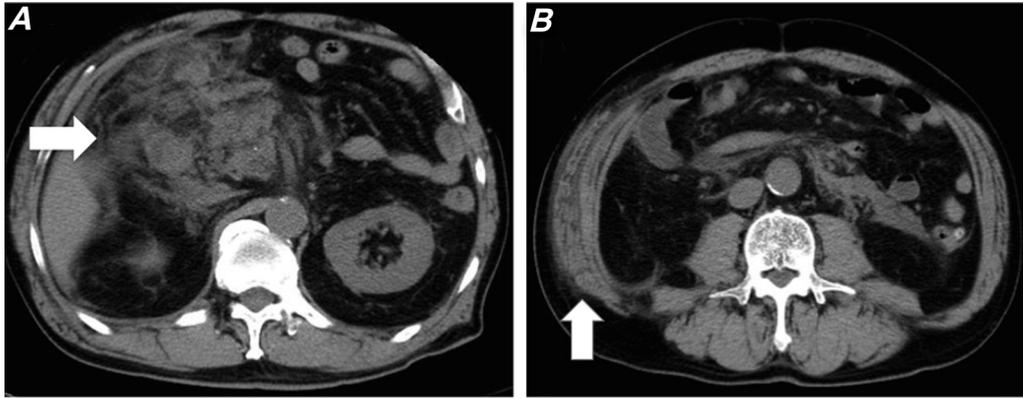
Abdominal noncontrast computed tomography (CT). An abdominal CT revealed an extension of extra pancreatic fluid and reaction into the (A) transverse mesocolon and small intestine mesentery, as well as (B) thickening of the lateral paries.
